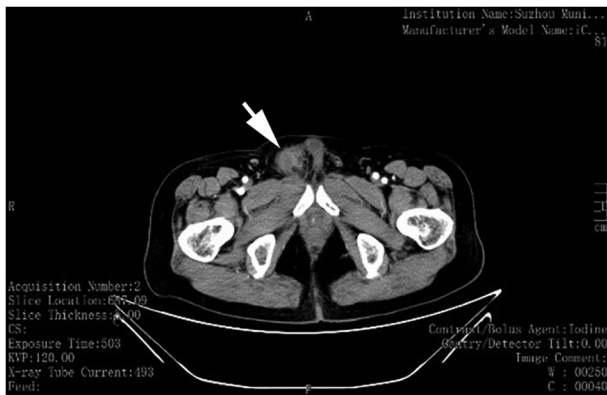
Contrast-enhanced abdominopelvic computed tomography demonstrates postsurgical alterations in the right scrotal region, with a soft-tissue density along the spermatic cord suggestive of recurrence, accompanied by sclerotic iliac bone lesions.
